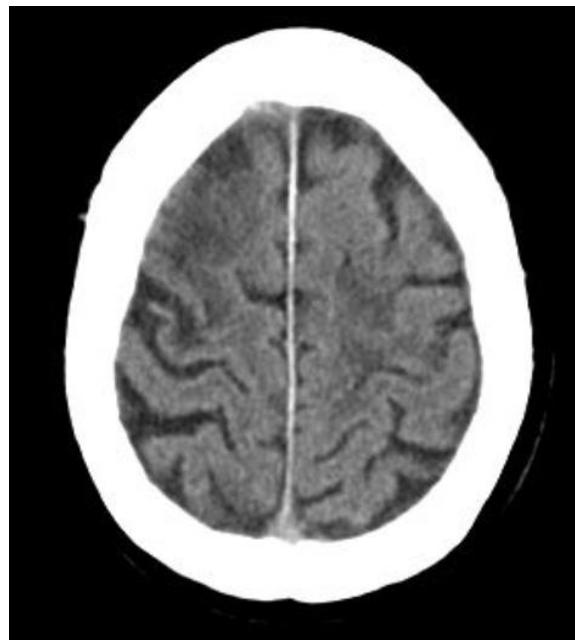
Cranial CT Scan - Day two of internal medicine hospitalization motivated by bilateral ischemic stroke
